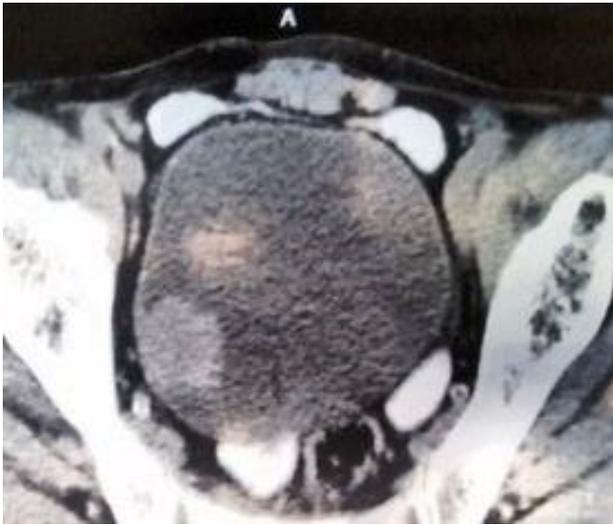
Computed tomography (CT) showed a solitary well defined lesion in right lateral wall region
